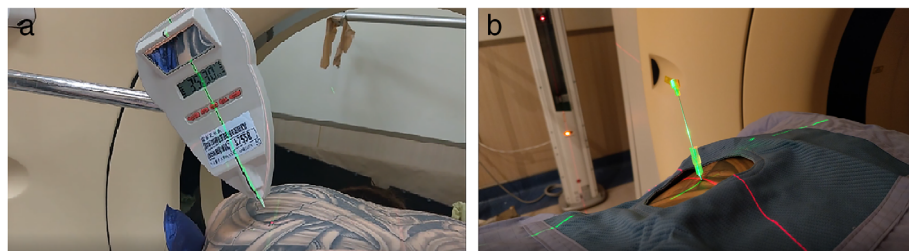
The laser angle guide assembly (LAGA) system was used to aid in the angle precision of puncture. (a) Angle of the LAGA was established according to the computed tomography (CT) scan. (b) Precise puncturing of the needle was achieved along the intersection of the two laser lines
